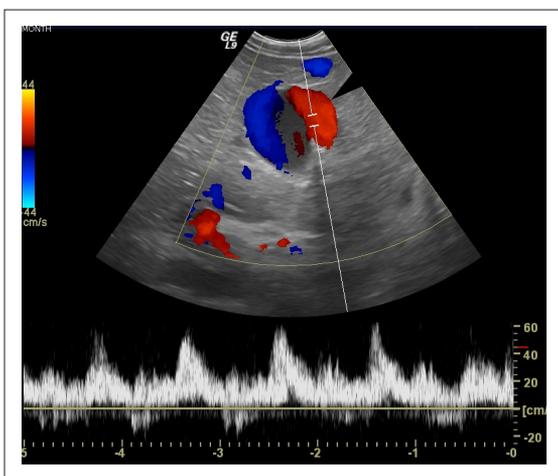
Doppler sonography of the liver. The spectral waveform of the vascular structure on the right (arrow) is consistent with arterial waveform.
